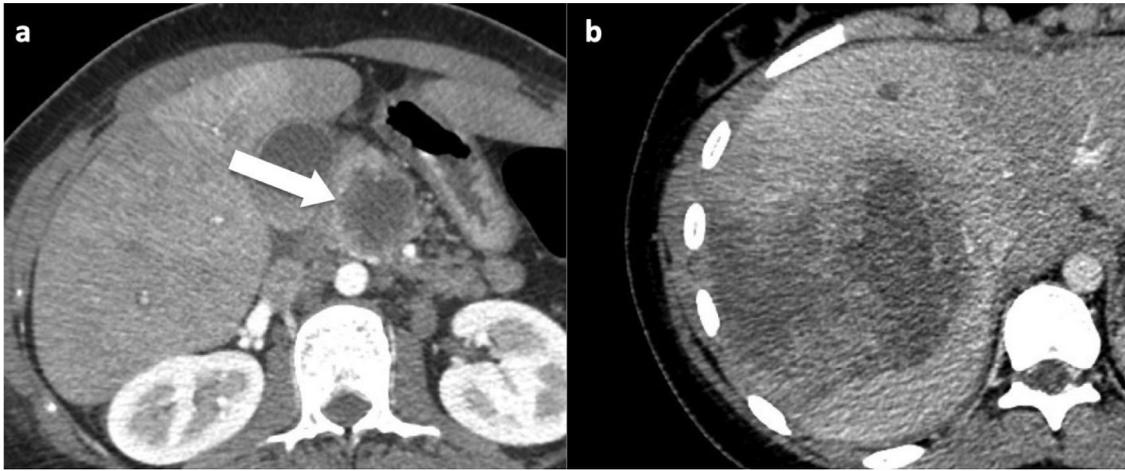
Anaplastic pancreatic adenocarcinoma in a 17-year-old female patient. Axial enhanced CT image obtained during the arterial phase (a) shows a large necrotic mass of the pancreatic body, presenting with predominant peripheral rim enhancement (arrow). Note the large metastasis of the right liver lobe (b) at the time of diagnosis. Biopsy confirmed an anaplastic type of pancreatic adenocarcinoma.
